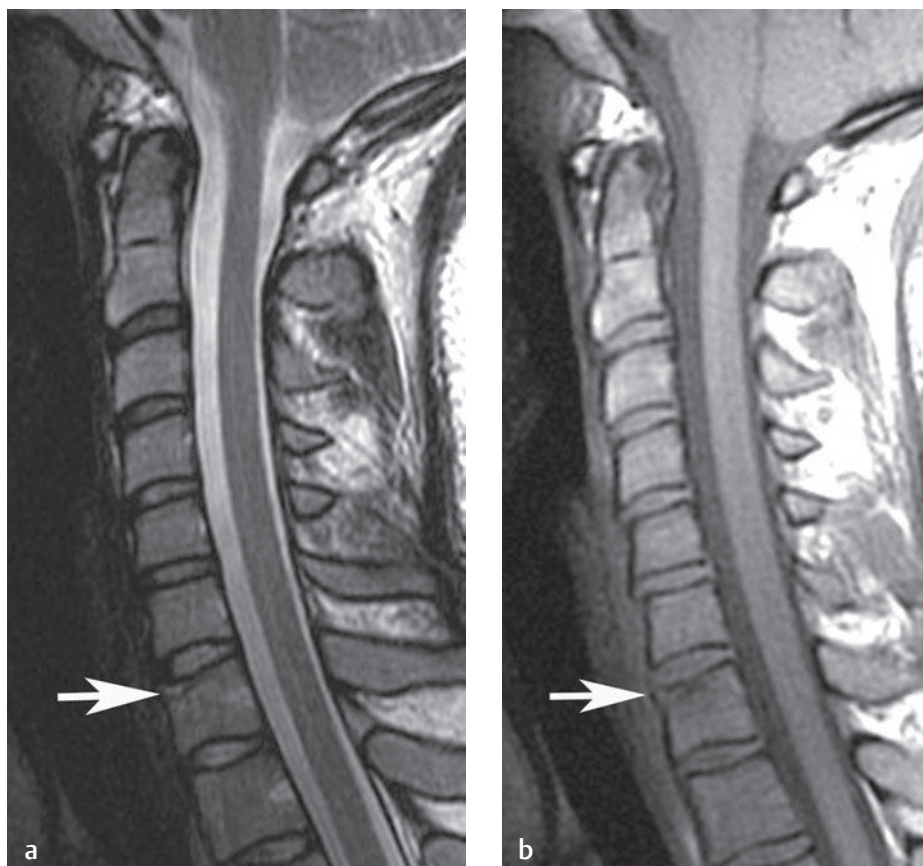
C7 vertebral compression fracture. Sagittal (a) T2-weighted and (b) T1-weighted images show the fracture (arrow on each) with minimal loss of height.[†]
